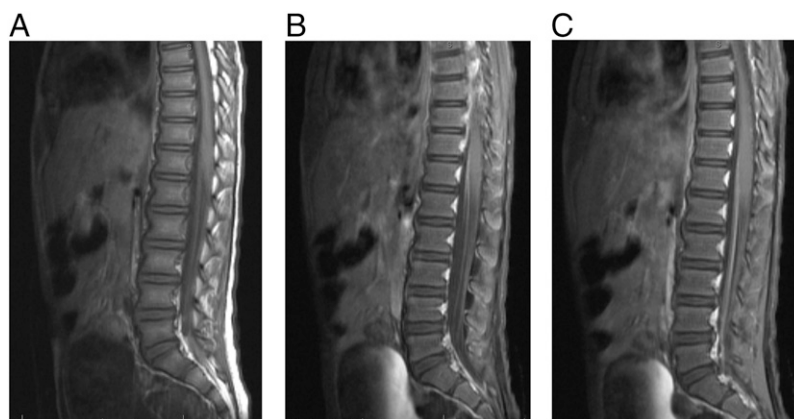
Sagittal T1 magnetic resonance images (A) without contrast and (B and C) with contrast. Abnormal enhancement of the ventral and dorsal nerve roots extending off the conus and filum terminale into the cauda equina can be seen.
